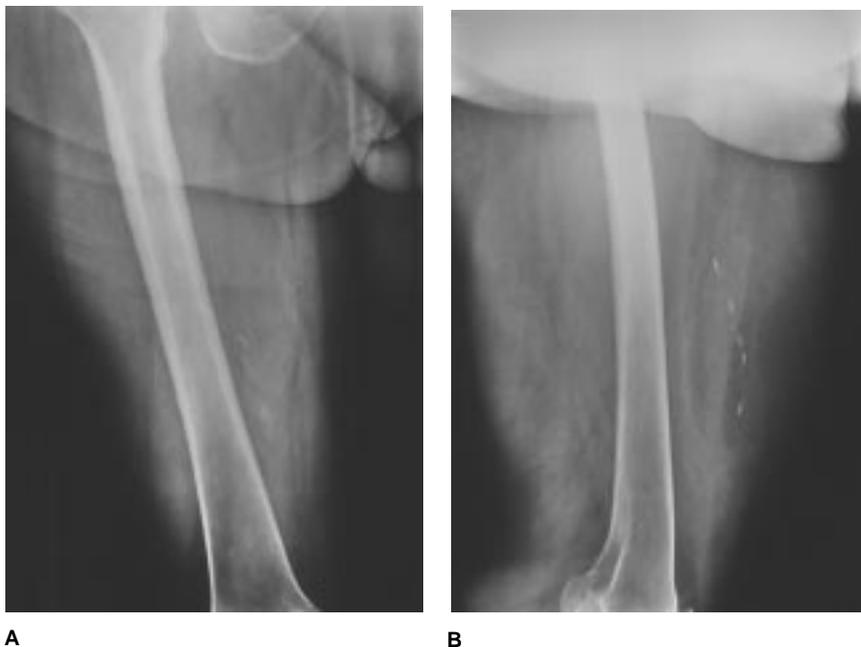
Anteroposterior (A) and lateral (B) plain radiographs demonstrate a large, low-density mass in the anterior thigh containing several foci of calcification.
